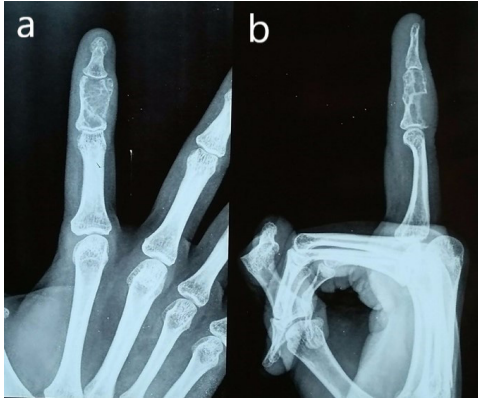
(a and b) Preoperative radiographic images showing giant cell tumor involving the middle phalanx of the right index finger (Campanacci III).
